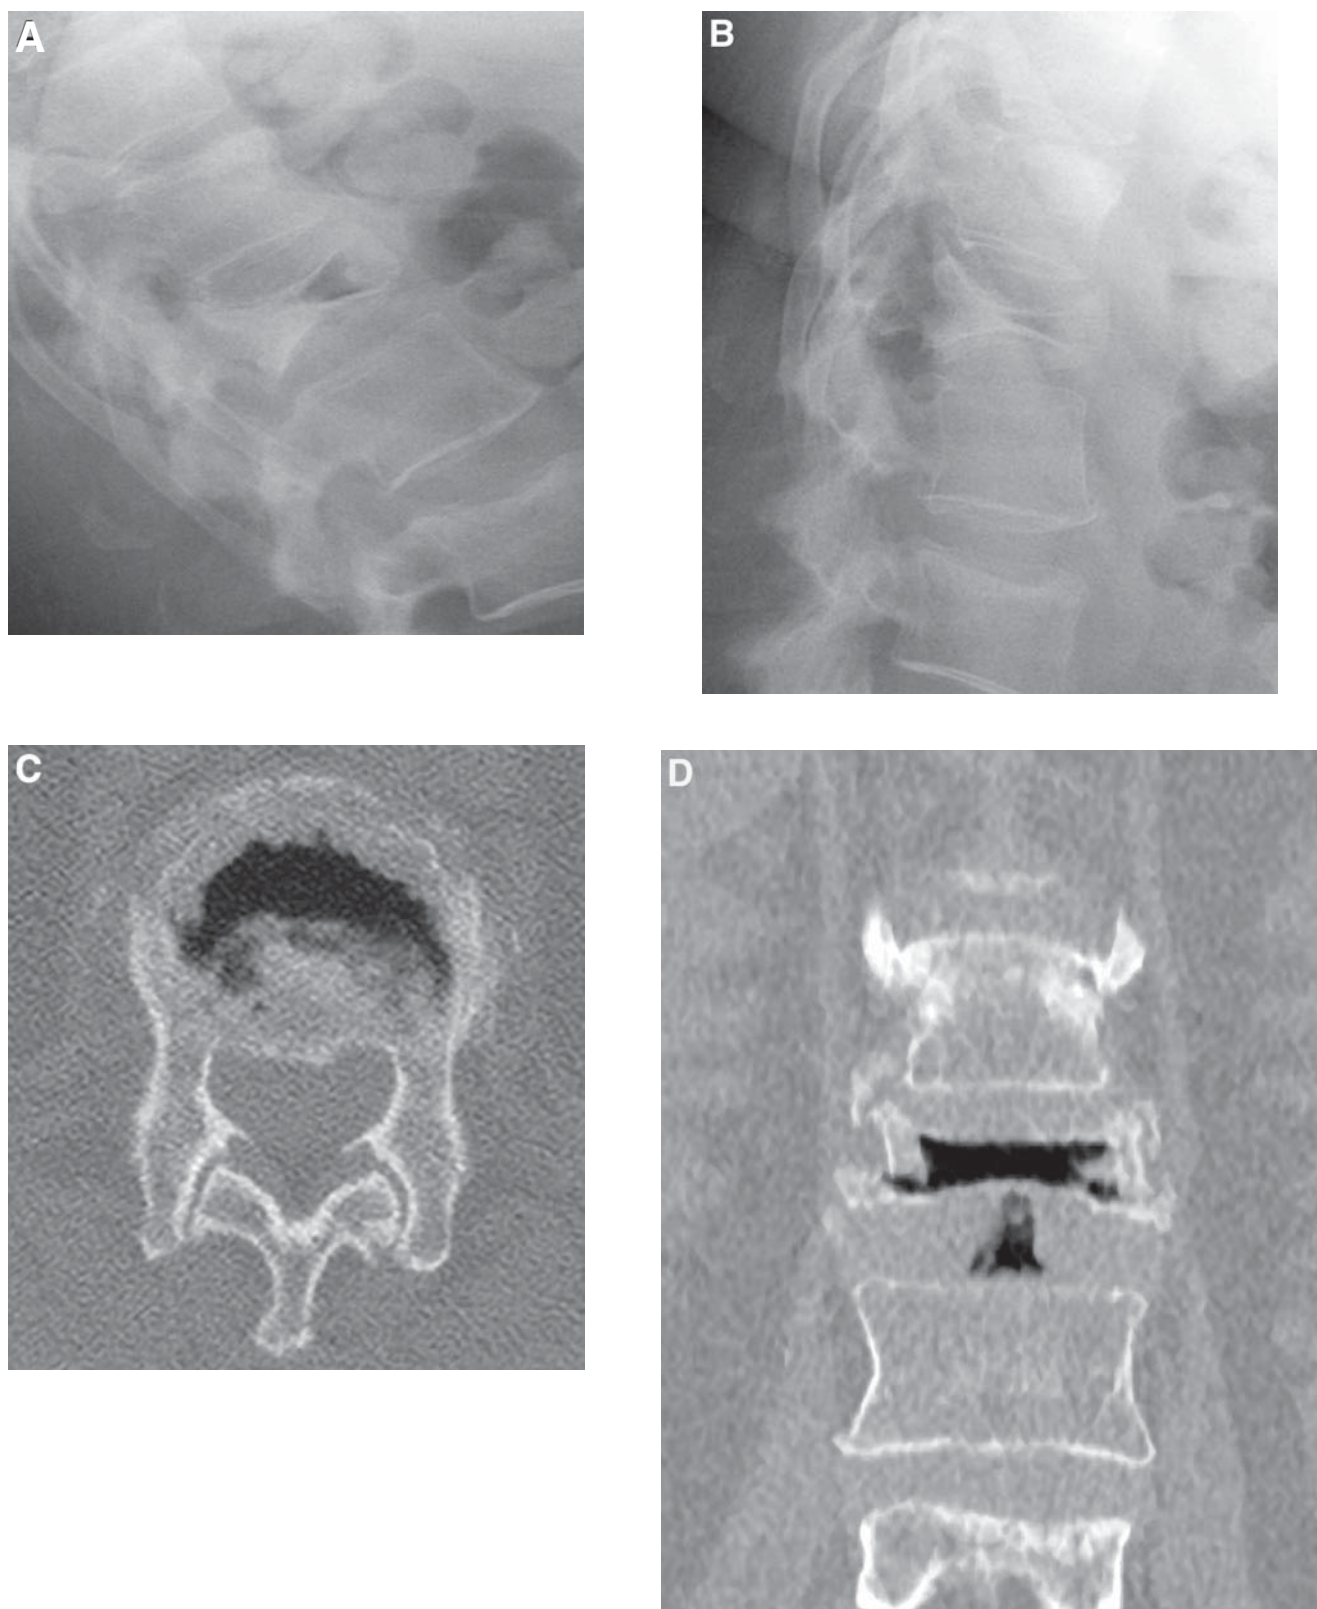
(A,B) Plain radiographs obtained in extension and flexion reveal vertebral collapse and an intravertebral vacuum cleft, which are characteristic of Kummell's disease (vertebral avascular necrosis). Note the positional change of vertebral height and size of the the vacuum cleft. Axial CT (C) and coronal CT reformation (D) confirm the presence of intravertebral gas. Note also that the axial CT image more accurately quantifies the degree of retropulsion as compared with the plain radiographs. (E) Sagittal STIR demonstrates high T2 signal fluid that has
